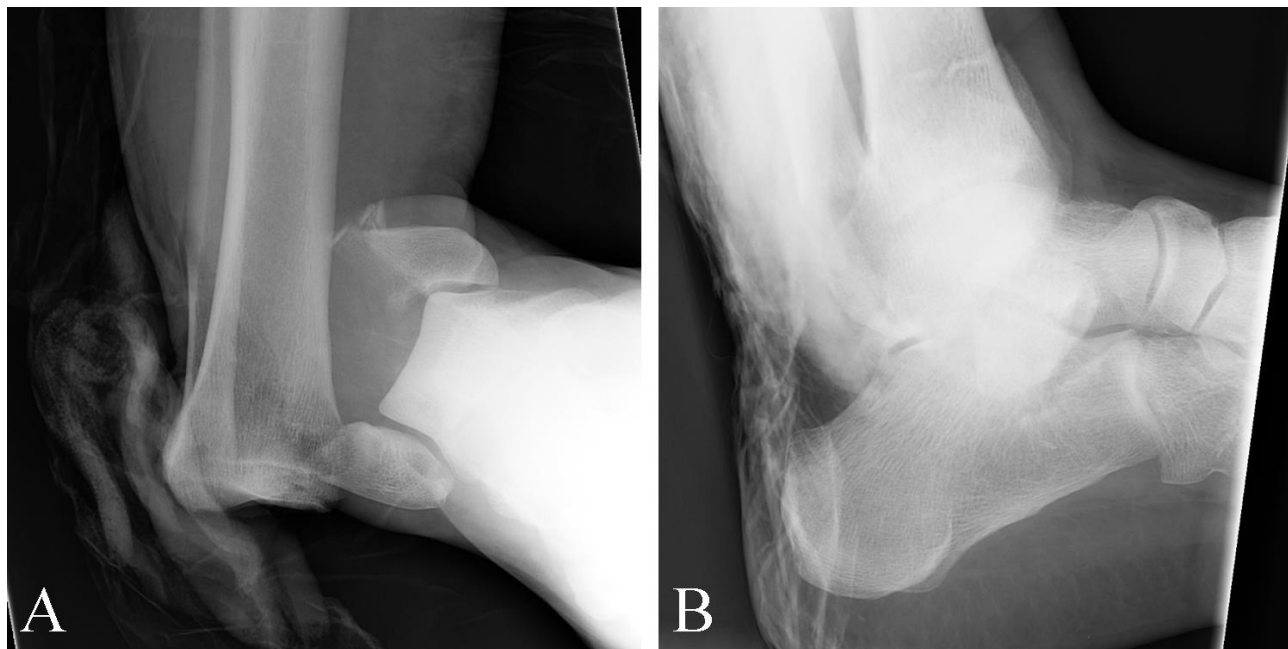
Fracture-dislocation of the ankle in a 46 year old man following a motor vehicle accident. A. AP plain film examination shows gross medial, proximal displacement of the talus. Note fractures of both the medial and lateral malleoli. B. Lateral plain film examination shows malalignment of the talus compared to the tibia, although this view clearly underestimates the true extent of derangement as seen on the frontal view.
